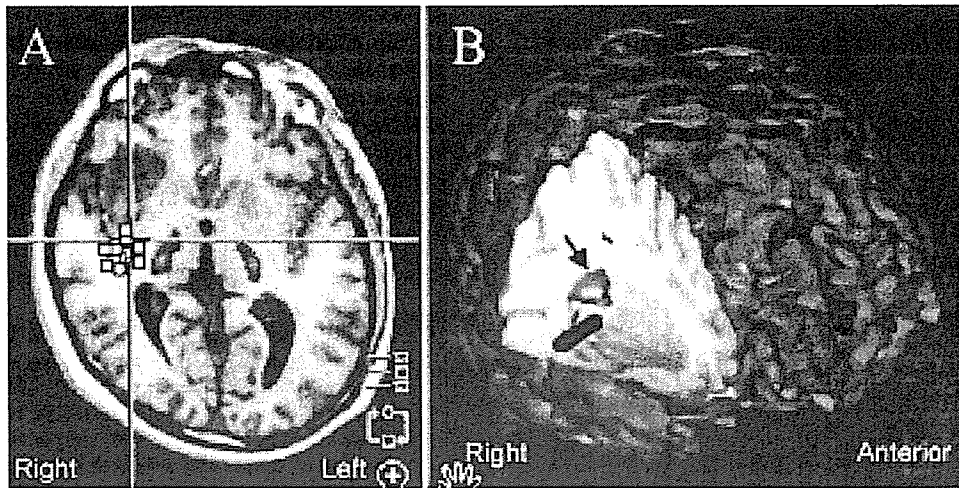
A: Two-dimensional axial MR image demonstrating that the posterior border of resection is close to the dipole accumulation in the superior temporal region. B: Three-dimensionally reconstructed intracranial data obtained in our patient, clearly showing that a tip of the navigation probe (dark gray elongated oval) indicates the anterior border of lexico-semantic dipole clusters (arrow).
